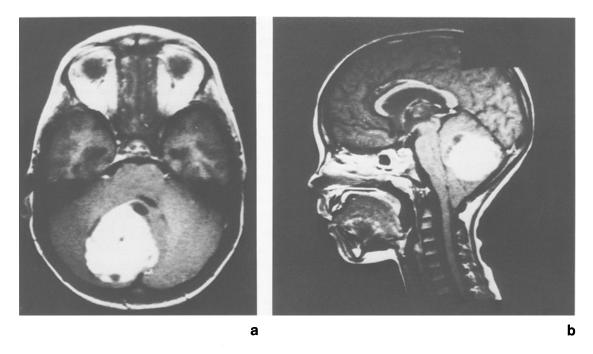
6.5-year-old boy with left-sided hemiparesis, progressive headache, and vomiting. Well confined tumour with striking Gd-enhancement in the right cerebellum and vermis. Multiple small cysts with a diameter of up to 1.5 cm are detectable at the rim of the tumour. (a) Axial, T1-weighted SE (TR: 400 ms, TE: 30 ms); (b) sagittal, T1-weighted SE (TR: 400 ms, TE: 30 ms)
